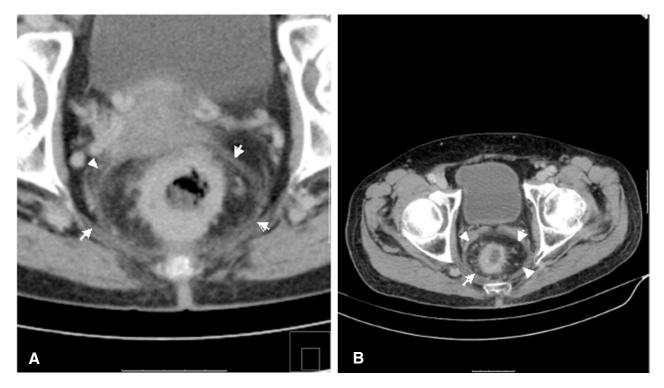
A: Transverse CT image of a T2 N1 rectal cancer. B: No signs of infiltration either in the perirectal fat or into the bladder (arrow: local lymph node).
